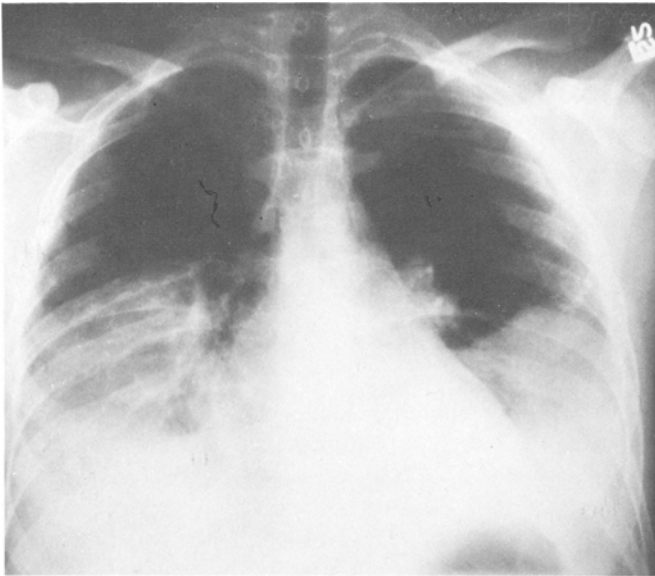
Posteroanterior chest roentgenogram obtained on admission. Bilateral dense lower lobe infiltrates are present
